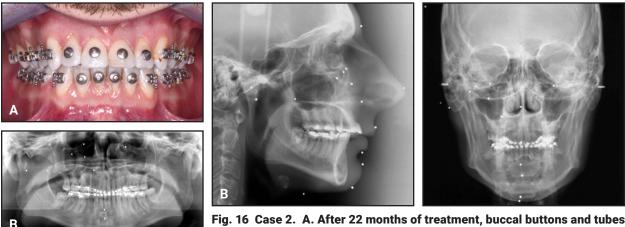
Case 2. A. After 22 months of treatment, buccal buttons and tubes bonded for postsurgical intermaxillary elastics. B. Presurgical radiographs.
